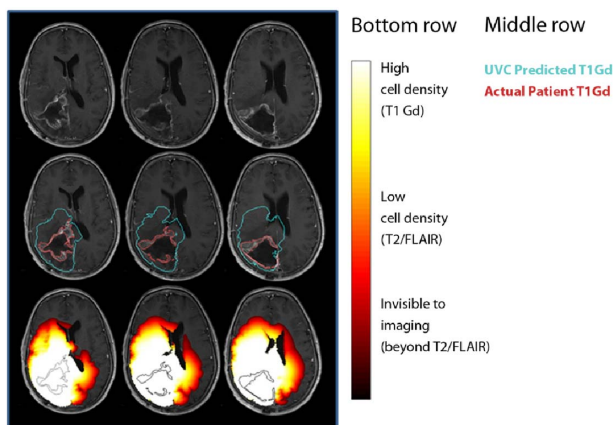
Comparisons between UVCs and posttreatment MRI scans. First row: posttreatment MRI. Second row: contours showing measured tumor on T1-Gd-enhanced scan (red) and UVC prediction of T1-Gd area (aqua). Third row: UVC tumor cell densities overlaid (white: high cell density and red: low cell density) on scan with T1-Gd measured tumor outline (black). Figure reproduced from [77, Fig. 7].
